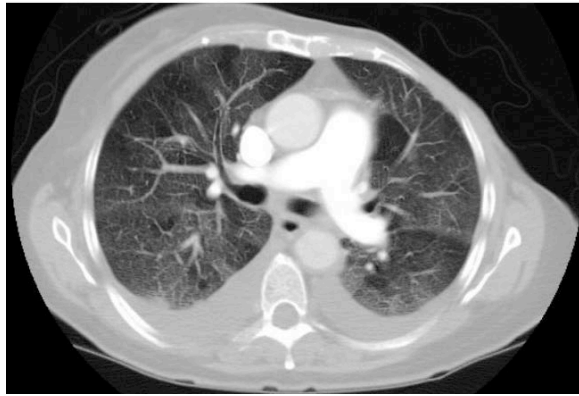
Small bilateral pleural effusions, right greater than left, was seen on CT of the chest with contrast. Patchy ground glass opacities were observed throughout the lungs bilaterally with upper lobe predominance. Interlobular septal prominence and mild dependent atelectasis also were noted.
